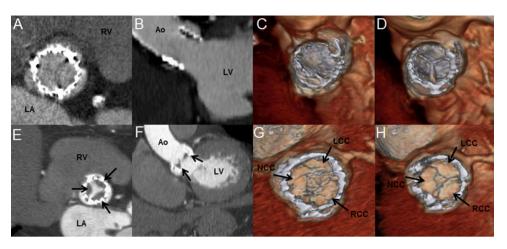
Multi-detector row computed tomography (MDCT) reconstructions after transcatheter aortic valve replacement with examples of normal structure of TAVR prosthesis ($panels\ A-D$) and transcatheter prosthesis with hypo-attenuated leaflet thickening and reduced leaflet motion ($panel\ E-H$). The double oblique reconstruction ($panel\ A$) on diastole of the transcatheter valve shows the stent frame and the leaflets without thickening and the coronal view of the transcatheter valve in systole ($panel\ B$) where the leaflets opened. The 3D volume renderings in systole ($panel\ C$) and diastole ($panel\ D$) show normal opening and closing of the prosthesis leaflets. In $panel\ E$, thickening of the prosthesis leaflets with hypo-attenuated lesions can be observed on the double oblique reconstruction. During systole, the leaflets remain immobile ($panel\ F$). $panel\ G$ and $panel\ F$ and $panel\ F$ and $panel\ F$ and $panel\ F$ are repairing in systole and diastole, respectively, with thickened leaflets that remain immobile (arrows). Ao, aorta; LA, left atrium; LCC, left coronary cusp of aortic valve; LV, left ventricle; NCC, non-coronary cusp of aortic valve; RV, right ventricle.
